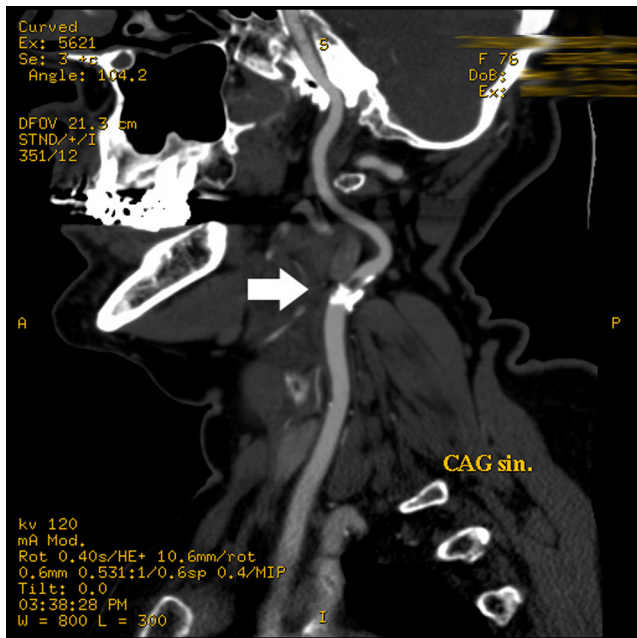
Computed tomography angiography showing severe stenosis of the left internal carotid artery at the left carotid bifurcation.
